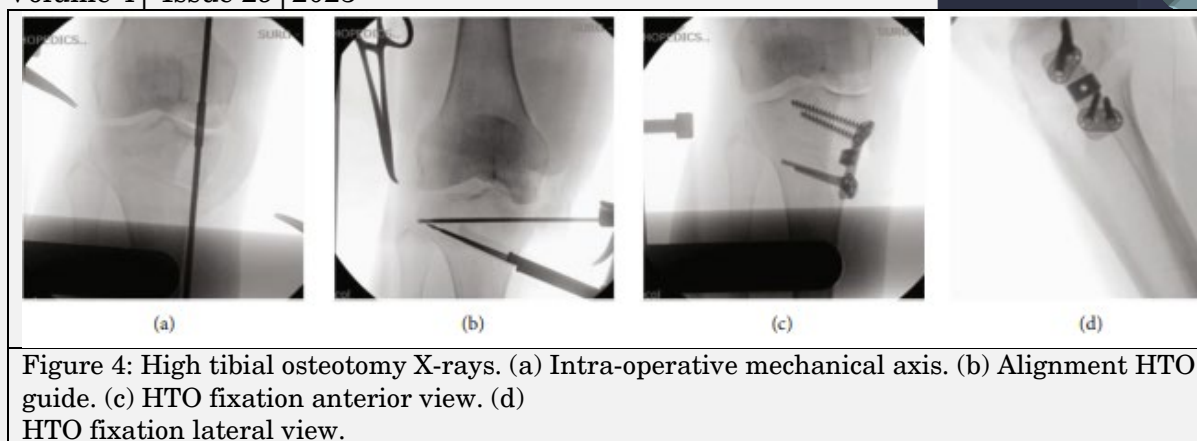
High tibial osteotomy X-rays. (a) Intra-operative mechanical axis. (b) Alignment HTO guide. (c) HTO fixation anterior view. (d) HTO fixation lateral view.
